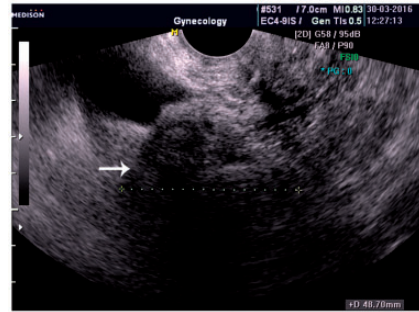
Pelvic ultrasound showing a structure of mixed echogenicity on the right side of the pelvis beside the uterus.
